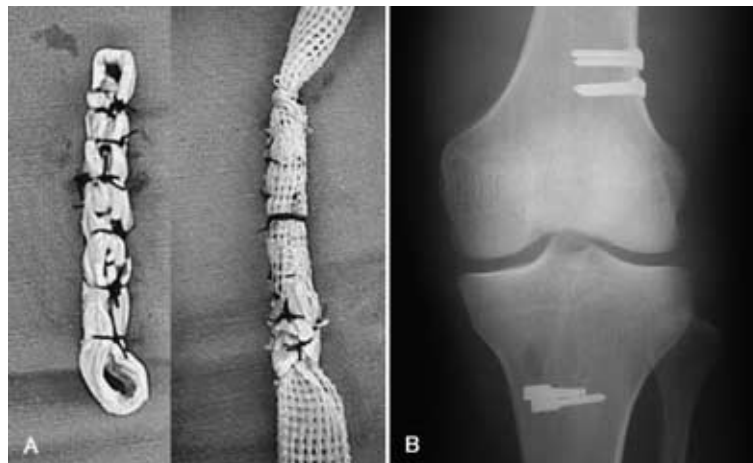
Substitutes for ACL (A), and a postoperative X-ray photograph (B).
